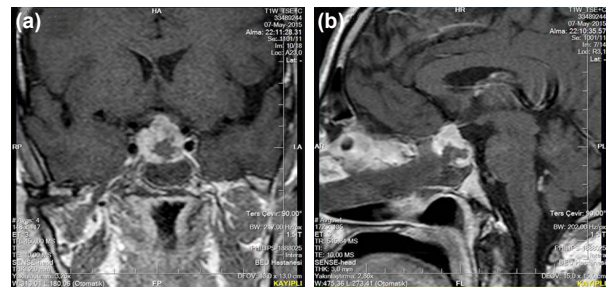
Surgical alterations secondary to intrasellar decompression as well as the tumor's suprasellar and peripheral parts seen on the second day after transsphenoidal surgery. (a) Coronal T1 C+ magnetic resonance imaging (MRI). (b) Sagittal T1 C+ MRI.
